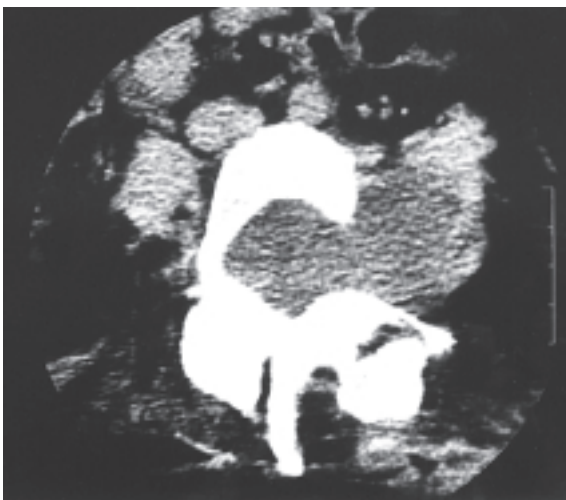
Neurogenic tumour of the psoas muscle in a 42-year-old woman with neurofibromatosis. Enhanced axial CT scan shows extension of a dumb-bell shaped hypodense mass through an enlarged left L3/4 intervertebral foramen to involve the left psoas muscle.
